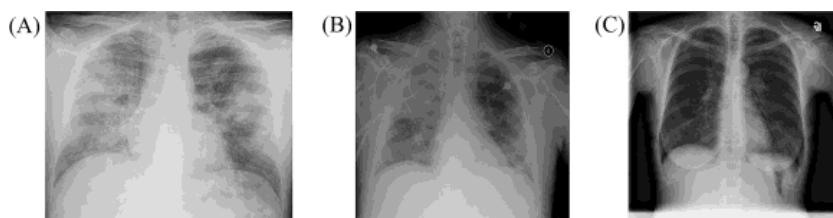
Representative CXR images of COVID-19 pneumonia, non-COVID-19 pneumonia, & healthy. CXR chest X-ray imaging, COVID-19 novel coronavirus disease. (A) COVID-19 pneumonia. (B) Non-COVID-19 pneumonia. (C) No pneumonia
